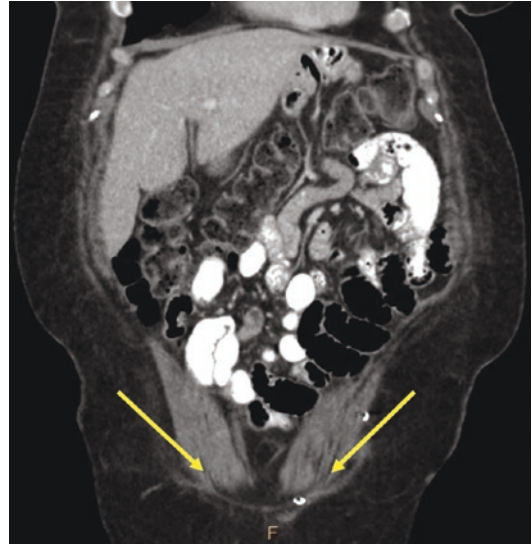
CT abdomen in the same patient displaying the inferior attachment of the paired rectus abdominis muscles (yellow arrows) at the pubic symphysis, and a widening of the inter-rectus distance
